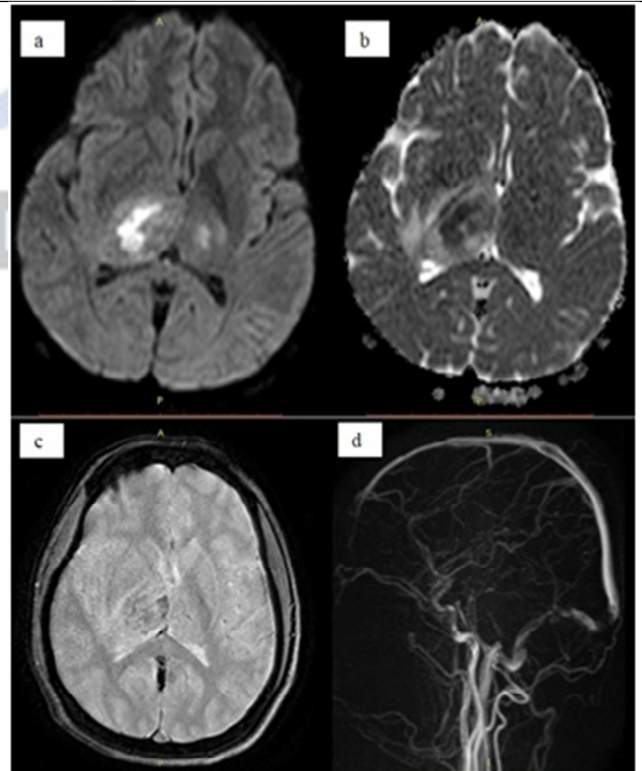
A case of postpartum day 3 presented with headache and seizures showing true restriction on DWI (a) with corresponding ADC (b) matching and areas of blooming on gradient sequence (c) in right thalamus. TOF MRV (d) showing thrombosis of straight sinus, internal cerebral veins, confluence of sinus, left transverse, left sigmoid and left internal jugular veins
